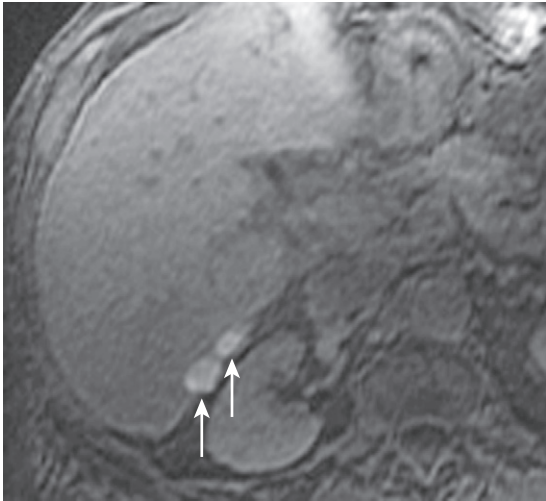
Hematoma. Axial T1-weighted fat-suppressed image after a liver biopsy reveals tandem small hyperintense hematomas in the posterior segment (*arrows*).
